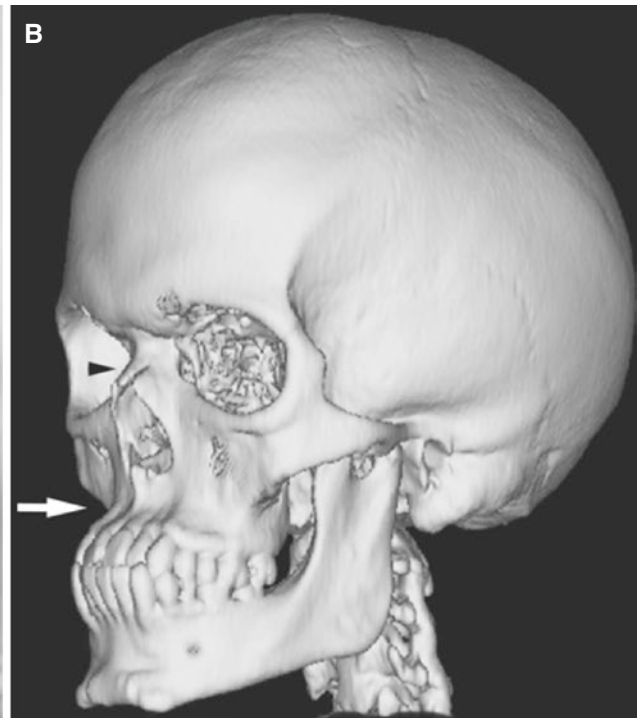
Achondroplasia; teenage. (A) 3D CT lateral view of the skin shows midfacial hypoplasia and saddle nose. (B) 3D CT image, oblique view, shows maxillary hypoplasia (*arrow*) and short, deformed, depressed nasal bone (*arrowhead*)
